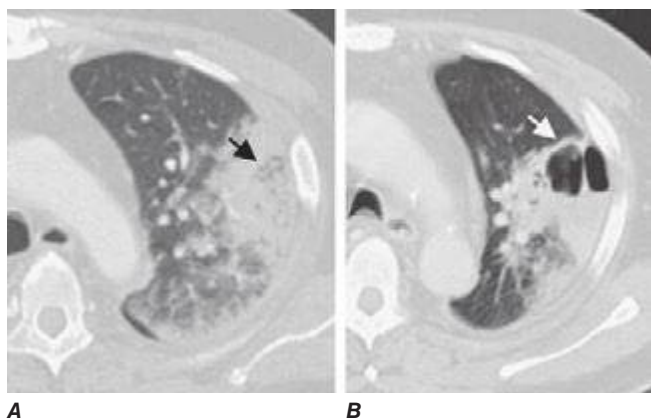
Representative chest CT scans demonstrating development of lung abscesses. This patient was immunocompromised due to underlying lymphoma and developed severe *Pseudomonas aeruginosa* pneumonia, as represented by a left lung infiltrate with concern for central regions of necrosis (panel A, black arrow). Two weeks later, areas of cavitation with air fluid levels were visible in this region and were consistent with the development of lung abscesses (panel B, white arrow). (Images provided by Dr. Ritu Gill, Division of Chest Radiology, Brigham and Women's Hospital, Boston.)
